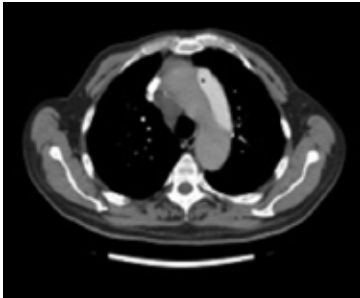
True and false lumen of dissection in arcus aorta at computed tomographic angiography.
